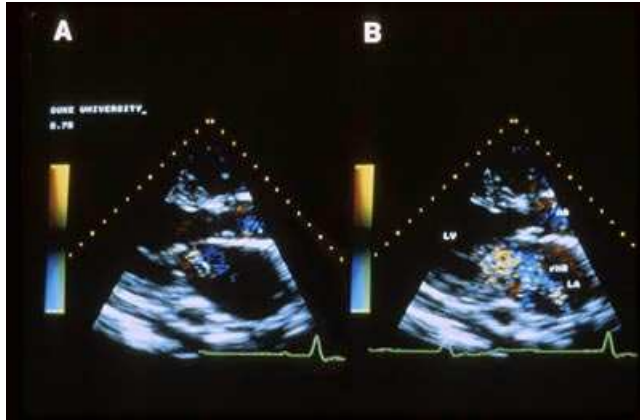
Parasternal long-axis images of mitral insufficiency demonstrating the effect of color gain on the area of a regurgitant jet.
